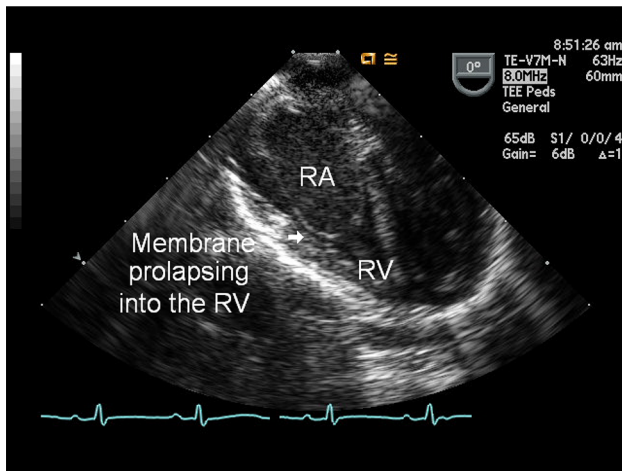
Transesophageal echocardiographic image shows the cor triatriatum dexter membrane prolapsing through the TV into the right ventricle (RV)
